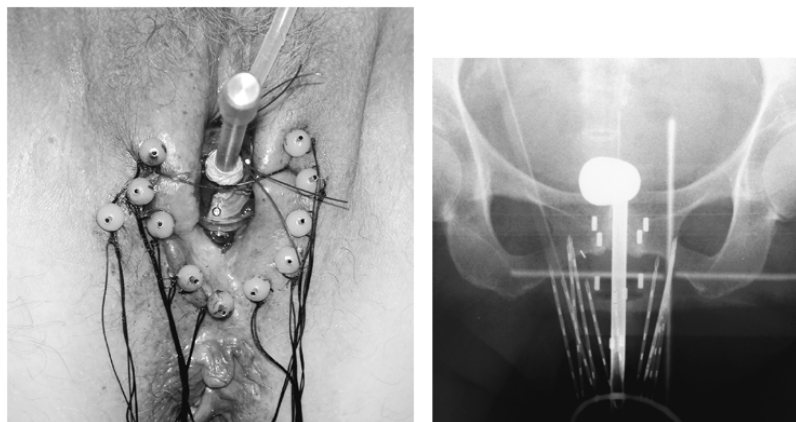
Interstitial implant for a stage II distal vaginal cancer. Needles are individually inserted transperineally; a finger is placed in the vagina while the needles are inserted to monitor the position of each needle relative to the tumor and mucosal surface. Left A Lucite cylinder in the vagina displaces uninvolved vagina from the needles. Right Postoperative radiographs show placement of the needles and can be used for dose calculations and treatment planning.
